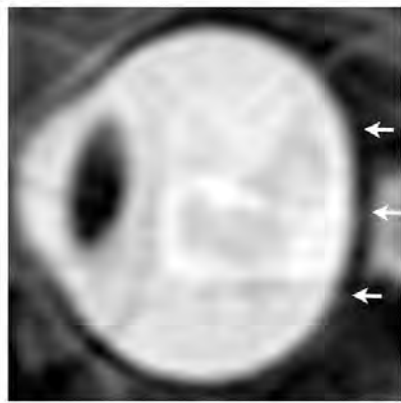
Sagittal oblique T2-weighted MR images. (a) Image of left eye before long-term exposure to microgravity. Note convexity of posterior globe (arrows). (b) Image of left eye after long-term exposure to microgravity. Note loss of convexity of the posterior scleral margin (arrows). (c) Image of right eye of different astronaut. Note two abruptly angulated foci (long arrows) in optic nerve sheath and posterior globe flattening (short arrows).
